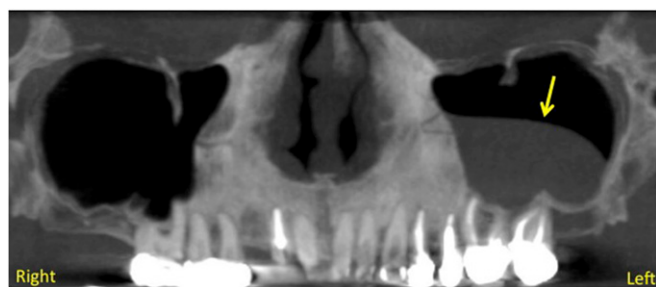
CBCT reconstructed panoramic view showing the mucous retention pseudocyst (arrow).
